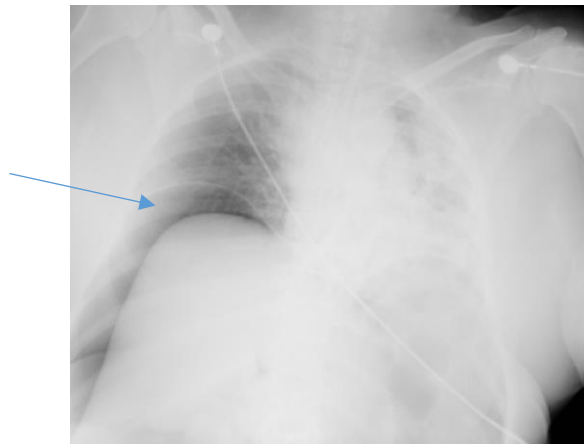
An upright chest X-ray demonstrates pneumoperitoneum (free air) under the left diaphragm (arrow), with pressure effect on the right liver lobe.
